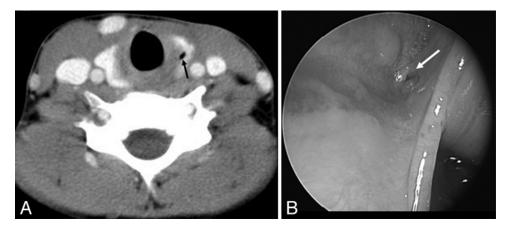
(a) Contrast-enhanced axial CT scan at the level of the thyroid gland which is showing a fourth branchial sinus tract remnant within the left lobe of the thyroid (*black arrow*). (b) The opening of the sinus tract at the apex of the pyriform sinus can be seen on this pharyngoscopy image (*white arrow*) (From Thomas B, Shroff M, Forte V, et al. Revisiting Imaging Features and the Embryologic Basis of Third and Fourth Branchial Anomalies. AJNR Am J Neuroradiol 2010; 31(4):755–60. Republished with permission.)
